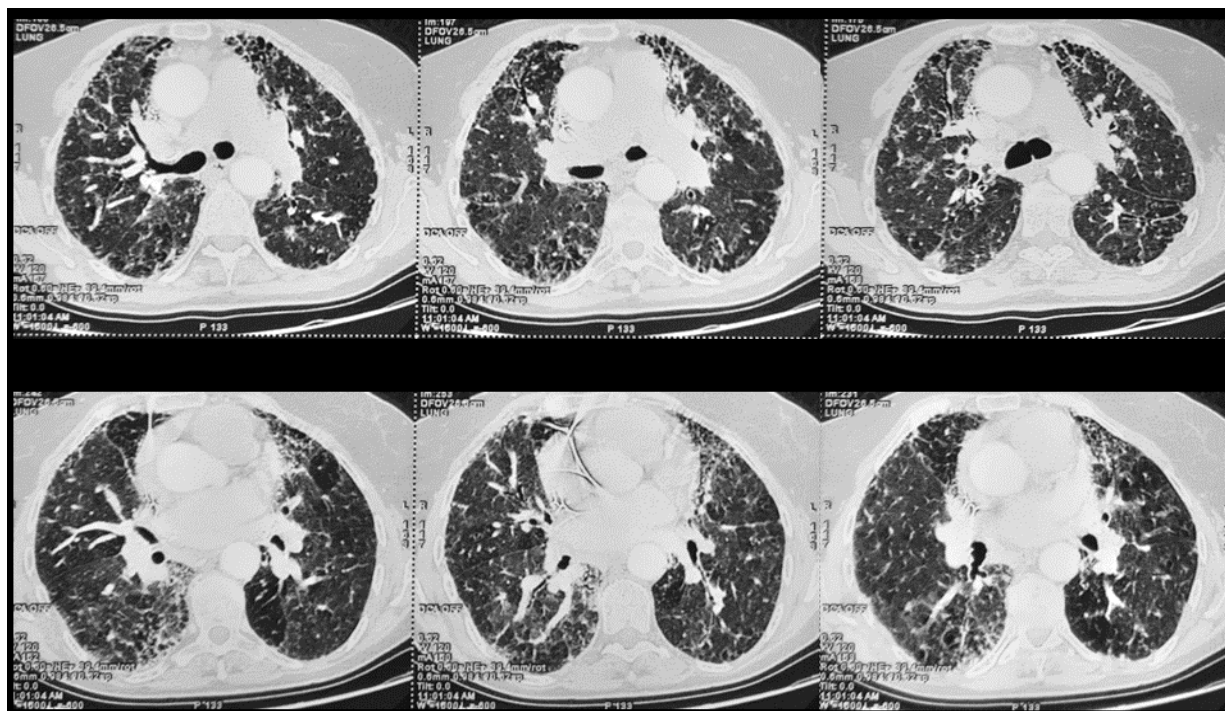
High-resolution computed tomography of Case 3. Fibrotic hypersensitivity pneumonitis with radiological progression during follow-up in the setting of persistent exposure despite repeated counseling and ongoing immunosuppressive therapy
